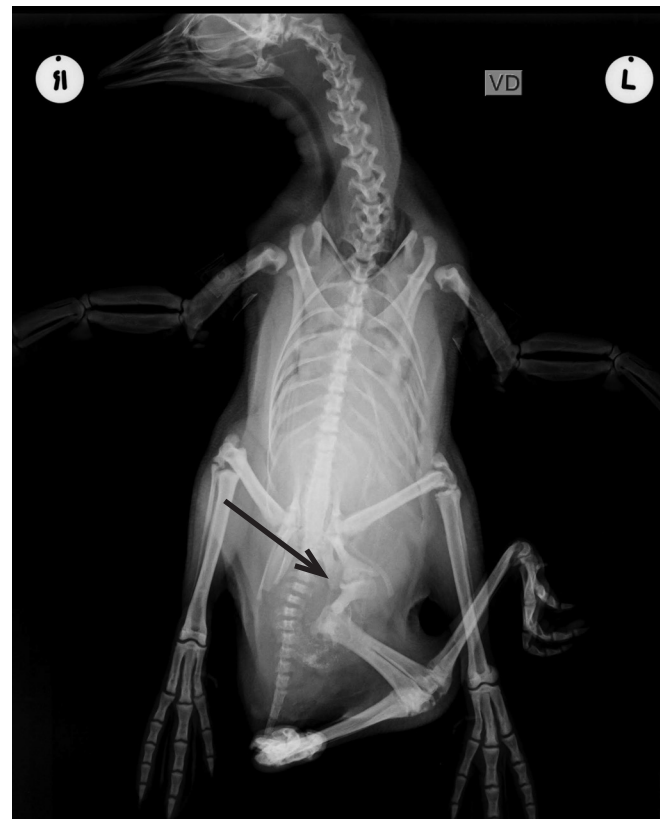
Radiograph of supplementary limbs of an African Penguin *Spheniscus demersus* chick; arrow indicates where both femur shafts were fused at the base of the ischium.
